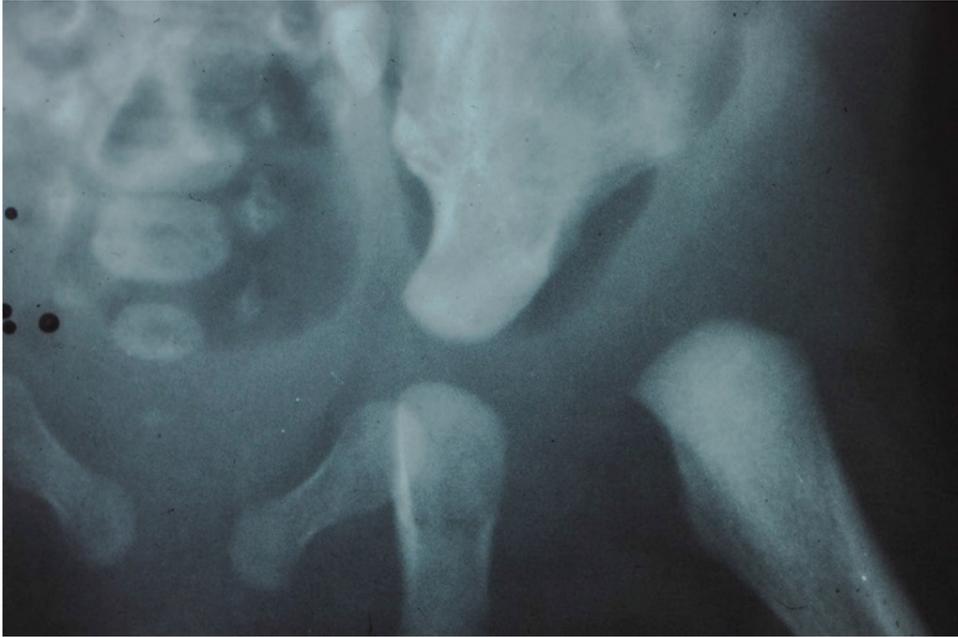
X-ray of left hip on day 1 using von Rosen technique (1) to show full dislocation with false acetabulum.
